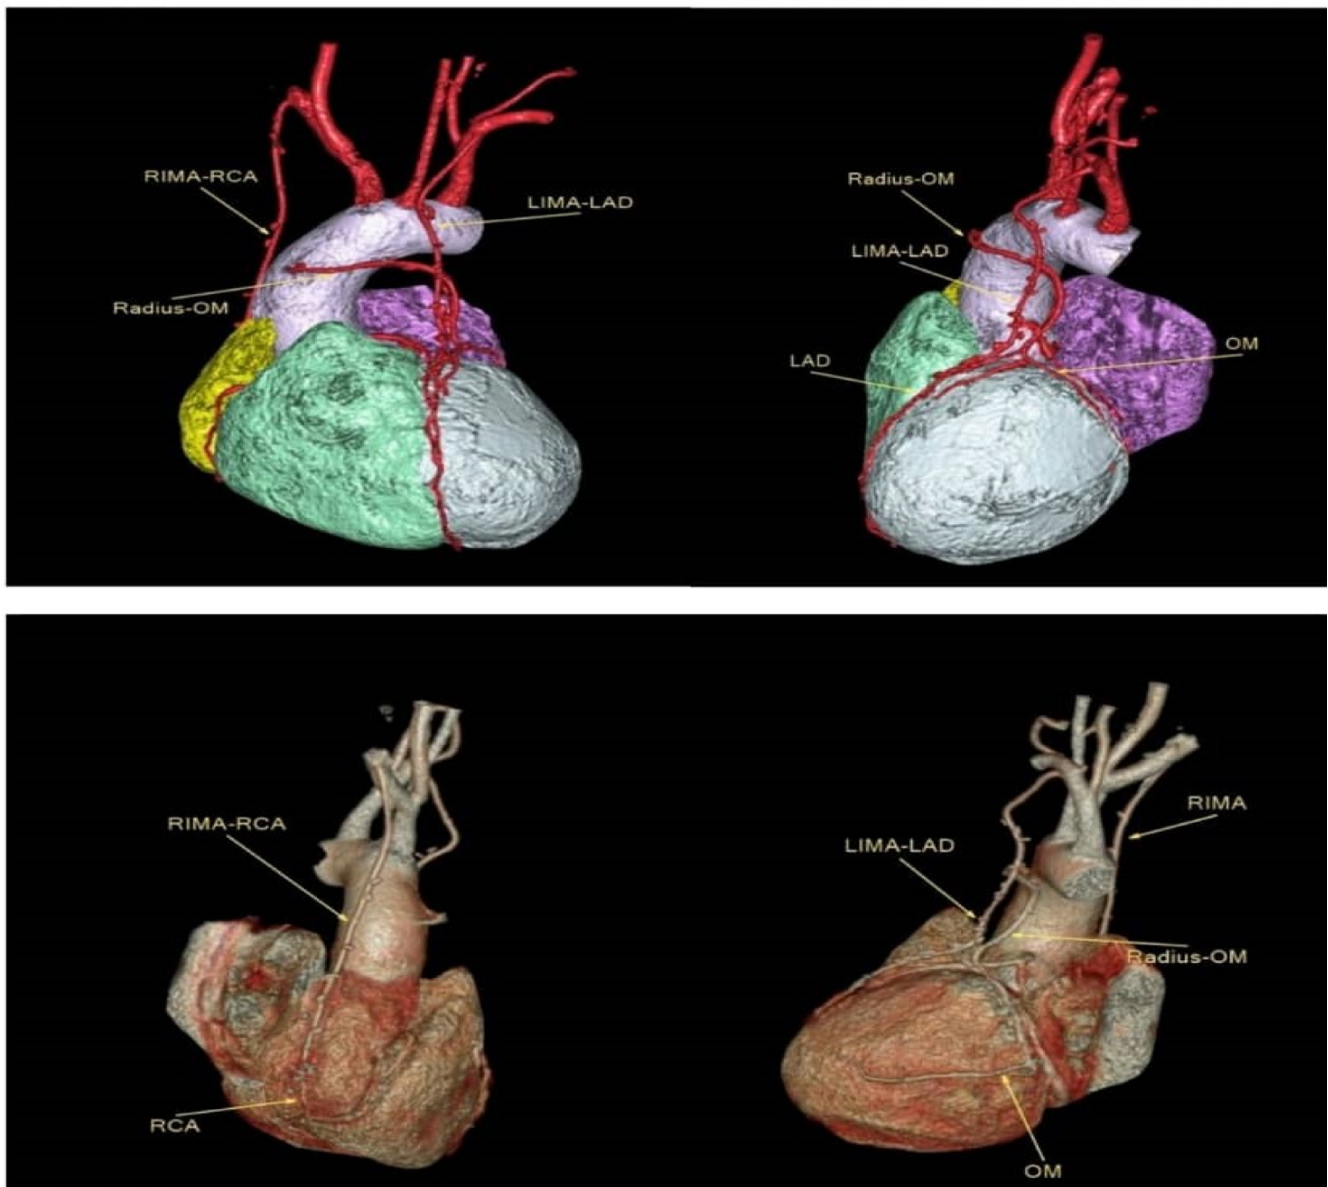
Complete revascularization after surgery using CT angiography.
